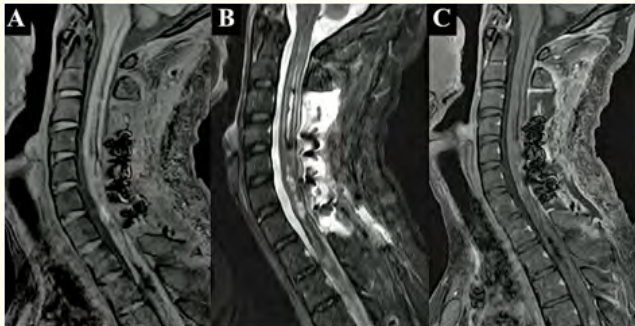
Postoperative cervical magnetic resonance imaging demonstrating surgical outcome.
